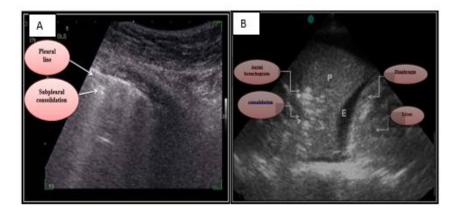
Lung ultrasound A- Longitudinal ultrasound view of a lung; irregularly spaced B-lines arising from a small juxta-pleural infectious site. B- Massive alveolar consolidation, transverse view of lung ultrasound; P=lung; E= pleural effusion
